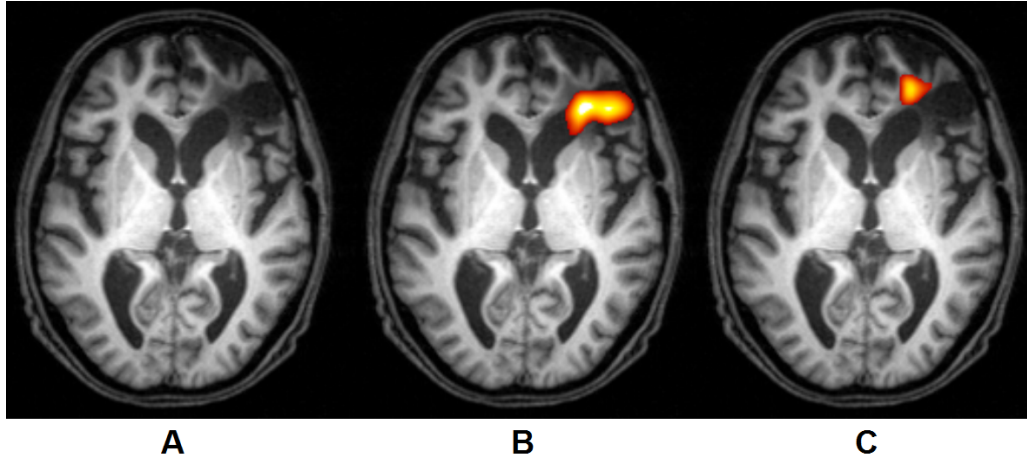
Patient MRI scan slice (A), with missing tissue map overlaid (B) and abnormal tissue map overlaid (C)
